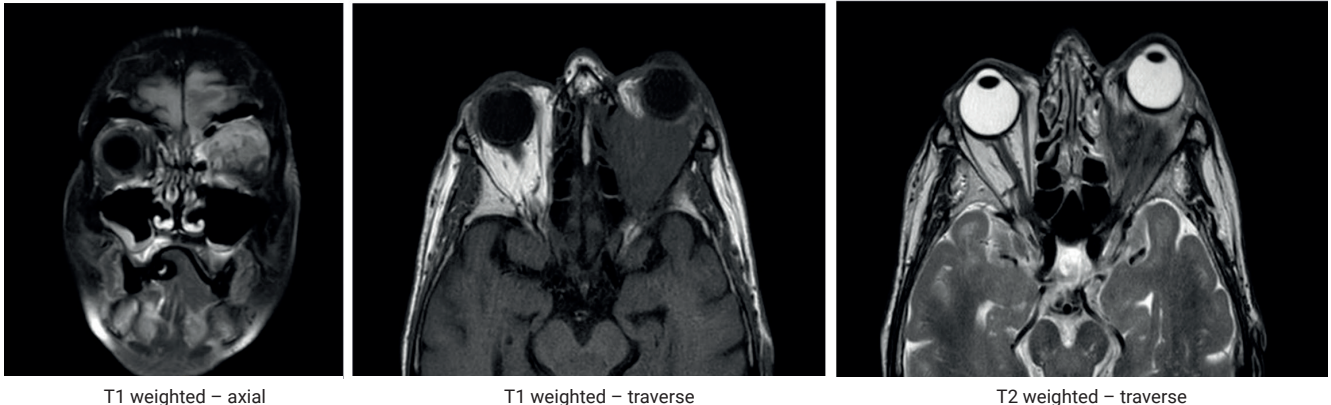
MRI head and orbit images of patient: (a) Axial T1 weighted image; (b) Transverse T1 weighted image; (c) Transverse T2 weighted image.
